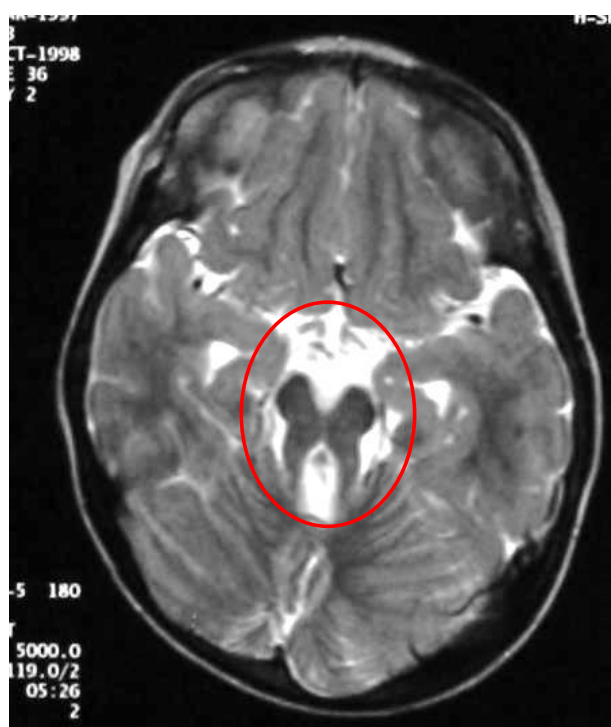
Brain MRI of Case 2 showing 'molar tooth' sign.
